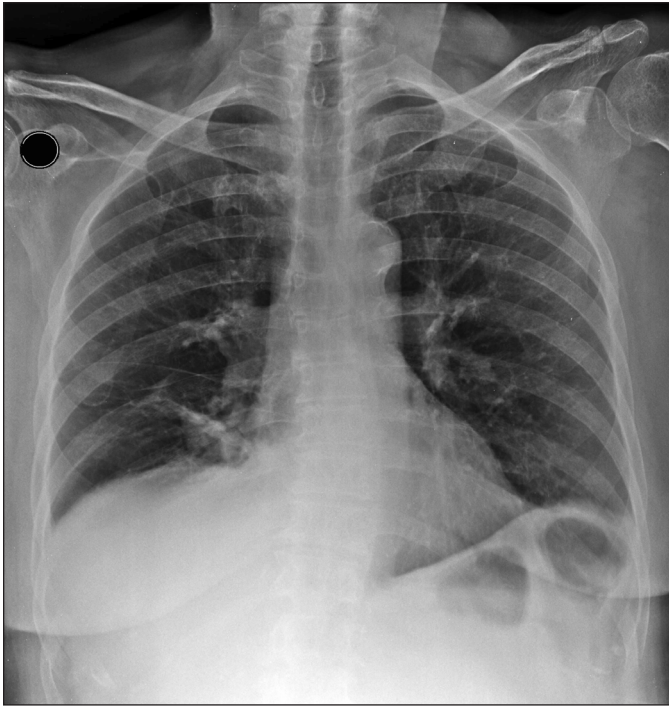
Chest radiograph 5 days after surgery does not show bowel loops interposed on the hepatic silhouette.
